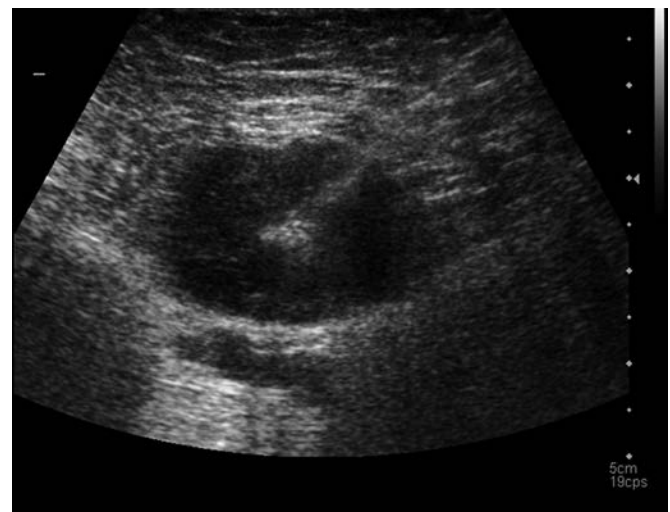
Ultrasound-guided fine needle aspiration from a lymph node in vulvar cancer.
